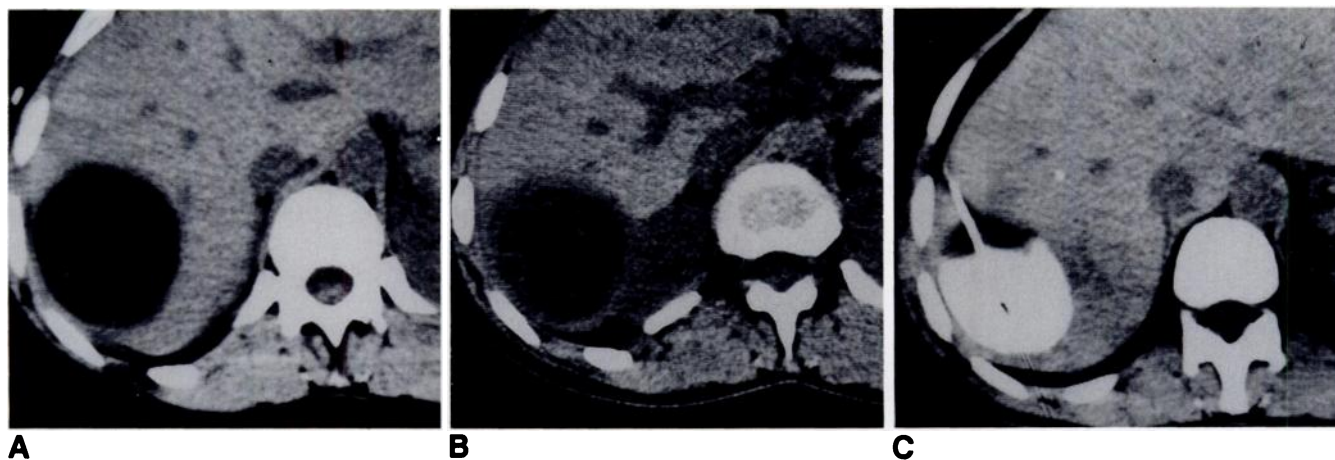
A, CT scan shows purely cystic mass 55 mm in diameter in posterior segment of right lobe of liver. B, After aspiration, detached lining of cyst is visible on CT scan. C, CT scan shows hypertonic saline in cavity.
